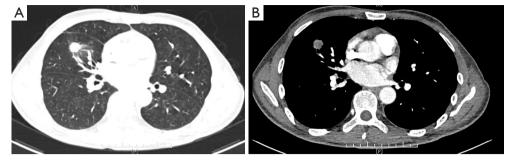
Chest CT scan showing the space occupying lesion in the middle lobe of the right lung. (A) Mediastinal window; (B) pulmonary window. Scale bar =10 cm. A, anterior; P, posterior; CT, computed tomography.
